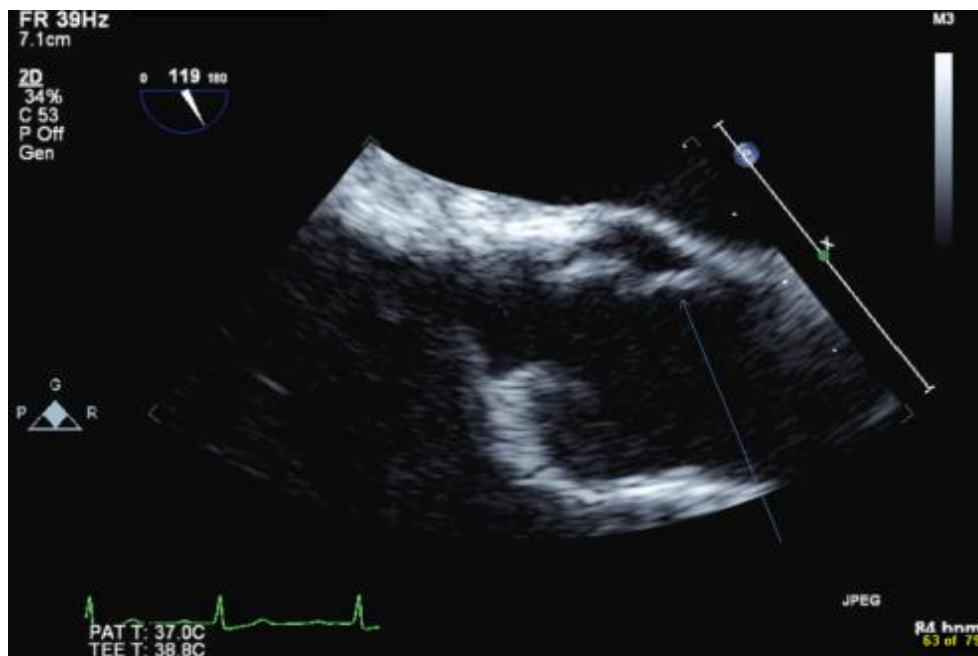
Transesophageal echocardiogram- LVOT AV view arrow pointing at mobile structure attached to aortic valve papillary fibroelastoma
